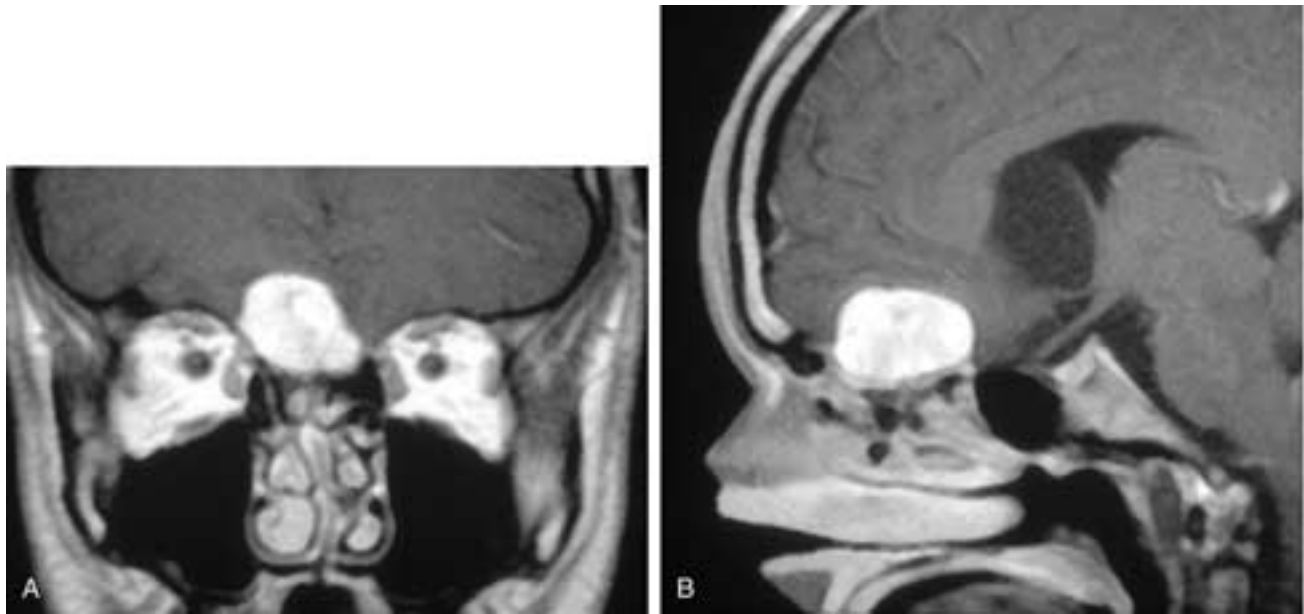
Coronal (A) and sagittal (B) T1-weighted, contrast-enhanced MR images show an ovoid mass sitting on the cribriform plate region and minimally displacing both the fovea ethmoidalis and the cribriform plate caudally. This was a rare schwannoma of the olfactory bulbs of the first cranial nerve. (Case courtesy of Dr. Geoffrey Parker.)
